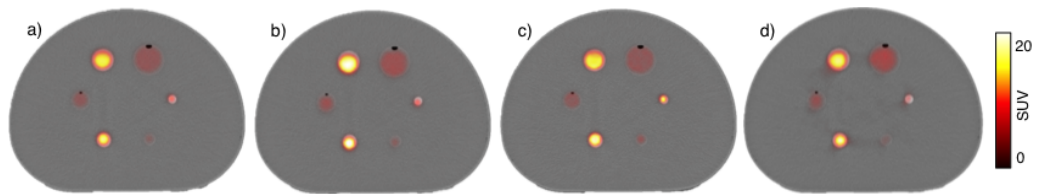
PET/CT fused transaxial view of Experiment 2. a) Standard OSEM reconstruction; b) OSEM reconstruction using the incorrect attenuation map derived from CT image with CM; c) Standard OSEM reconstruction with application of an Anatomy-Based Resolution-Recovery technique; d) MAP reconstruction with anatomical prior
